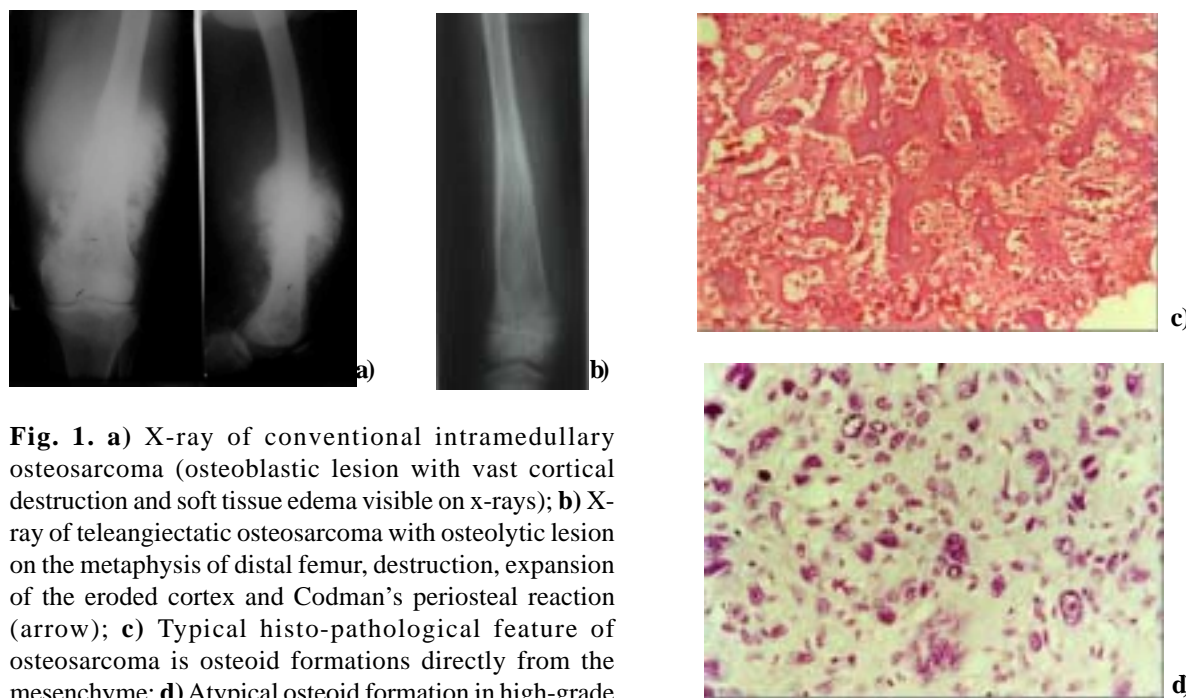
a) X-ray of conventional intramedullary osteosarcoma (osteoblastic lesion with vast cortical destruction and soft tissue edema visible on x-rays); b) X-ray of teleangiectatic osteosarcoma with osteolytic lesion on the metaphysis of distal femur, destruction, expansion of the eroded cortex and Codman's periosteal reaction (arrow); c) Typical histo-pathological feature of osteosarcoma is osteoid formations directly from the mesenchyme; d) Atypical osteoid formation in high-grade anaplastic osteosarcoma typifies the diagnosis.
